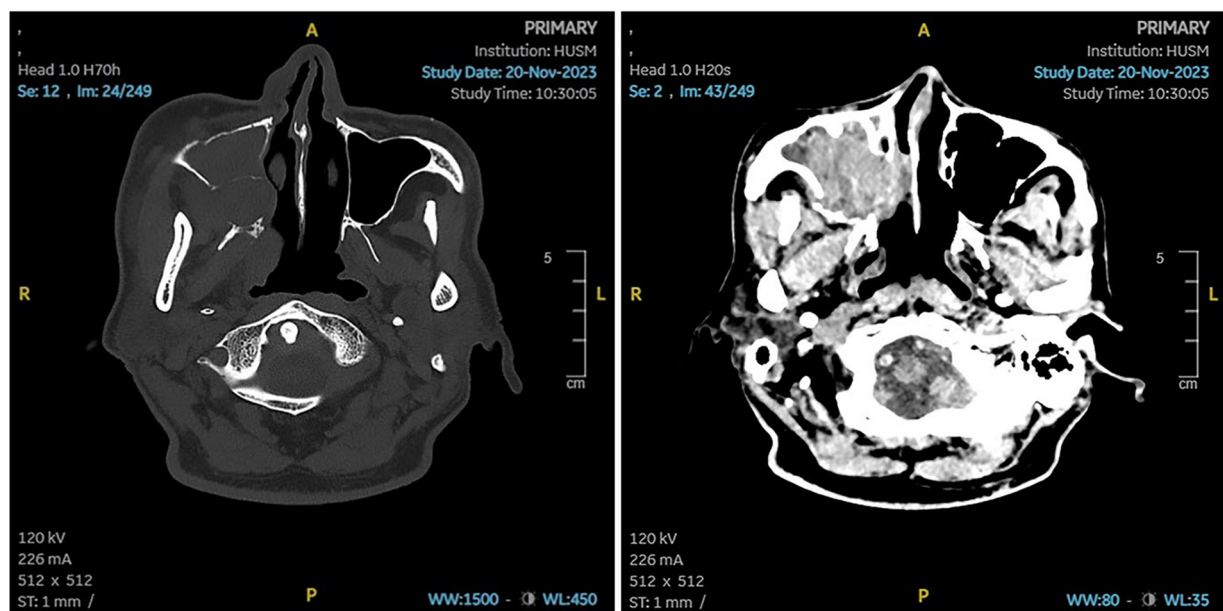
CT-scan (axial) images of the patient. A large tumour mass was noted, without contrast (left), occupying and causing expansion in the right maxillary antrum, and more tumour delineation was observed upon enhancement with contrast (right).
